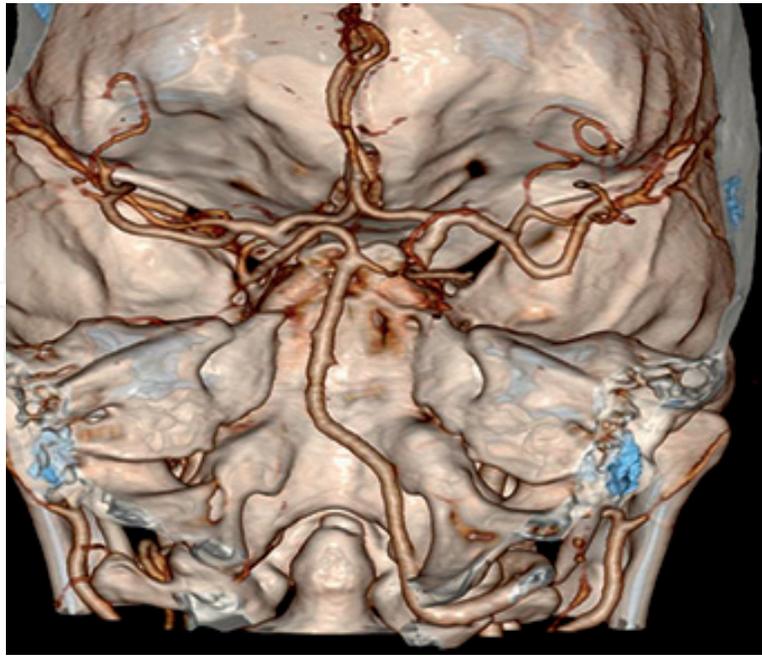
Angio-CT of the vertebrobasilar system vascular anomaly in the female patient. Developmental anomaly in the form of: the basilar artery that is an extension of the right vertebral artery. The left vertebral artery continues into the posterior inferior cerebellar artery.
